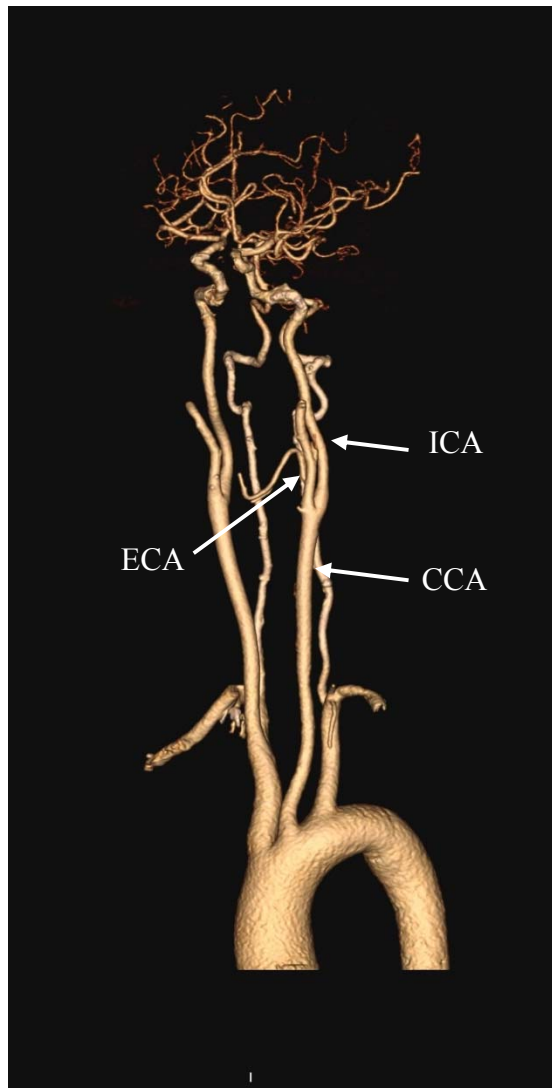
Computed tomography angiography showing a complete view of a normal carotid artery, including common carotid artery (CCA), carotid bifurcation, internal carotid artery (ICA) and external carotid artery (ECA), which is the critical pathway of blood flow from the thoracic aorta to vessels in the brain. (From Zhongshan Hospital of Fudan University, Shanghai, China)
